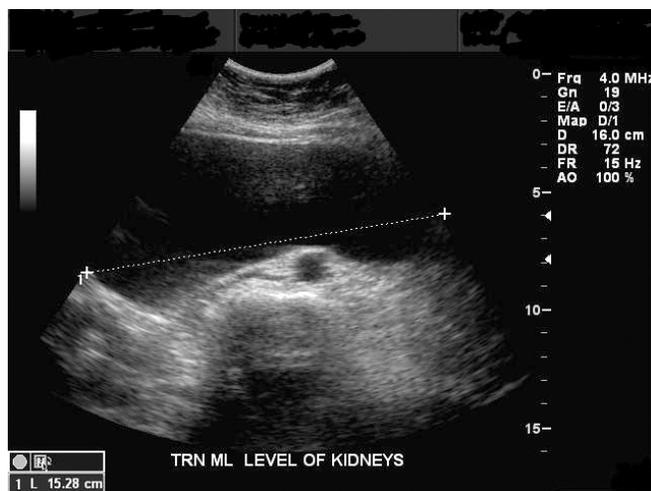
Ultrasound image of the same simple-appearing cystic mass
